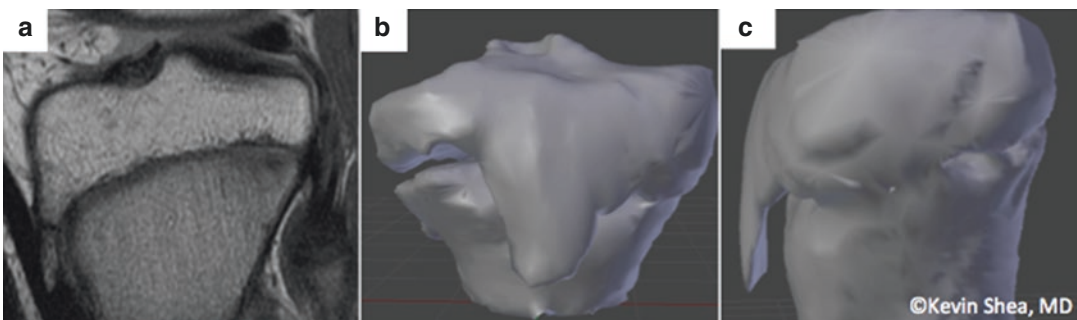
Sagittal MRI (a) and frontal (b) and side view (c) of 3D models identifying the tibial tuberosity in a skeletally immature knee. Published with kind permission of © Kevin Shea 2017. All Rights Reserved
